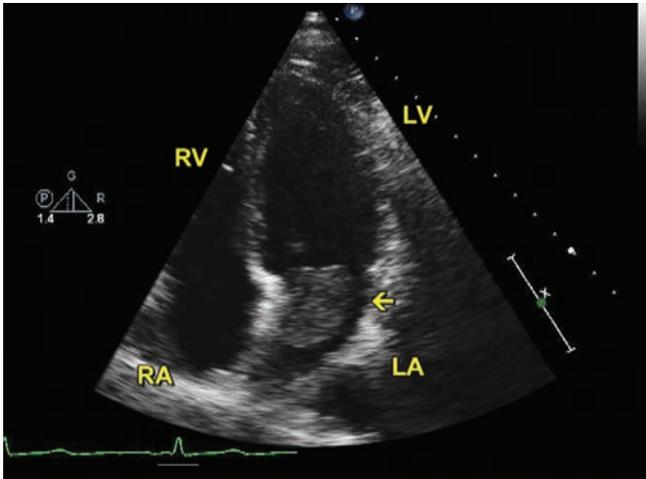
Transthoracic echocardiogram apical four chamber view of the left atrial mass (arrow).
